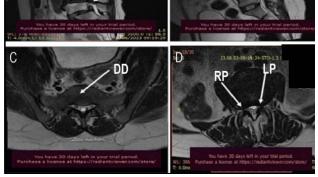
MRI sagittal view of the lumbar spine showing disc desiccation, bulge/prolapse, diffuse disc bulge, right and left paracentral disc bulges. D- Disc desiccation, B- Bulge, DD- Diffuse disc, RP-Right paracentral, LP-Left paracentral Changes and MRI -Magnetic resonance imaging.
